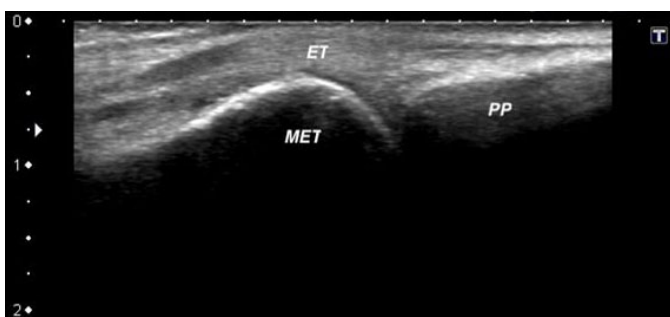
B-mode ultrasound in the sagittal plane of the left fourth digit at the metacarpophalangeal level. Note the soft tissue peritendinous extensor thickening, indicating functional enthesitis.
